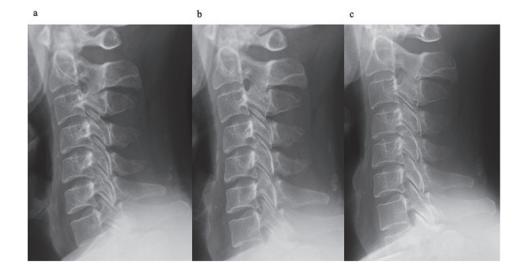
Radiographic images obtained in the sagittal plane (cervical global angle) showing patient progress. (a) At initial onset (5.3°); (b) 5 years after initial onset (before AM) (0.1°); (c) 7 years after initial onset (2 years after AM) (5.1°).
